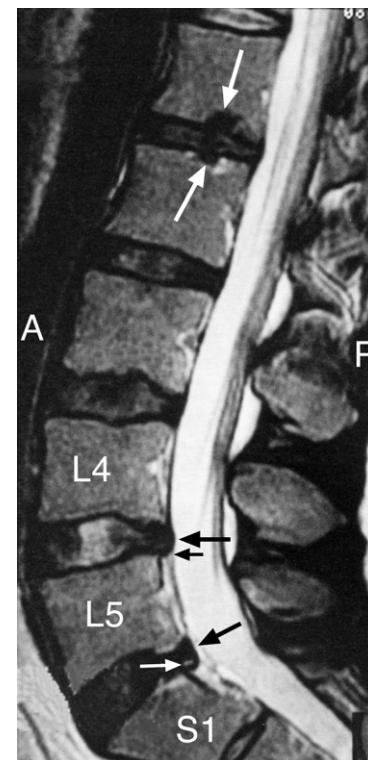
Lumbar spine MRI sagittal T2-weighted image. Note the posterior bulging discs at the L4-5 and L5-S1 levels (arrows) that touch, and at L4-5, elevate the posterior longitudinal ligament and compress the pain sensitive anterior surface of the dural tube (small black arrow). In addition, there is a tear (small white arrow) in the L5-S1 disc posteriorly. Schmorl's nodes are present in the endplates on each side of the L1-2 intervertebral disc (long white arrows).
